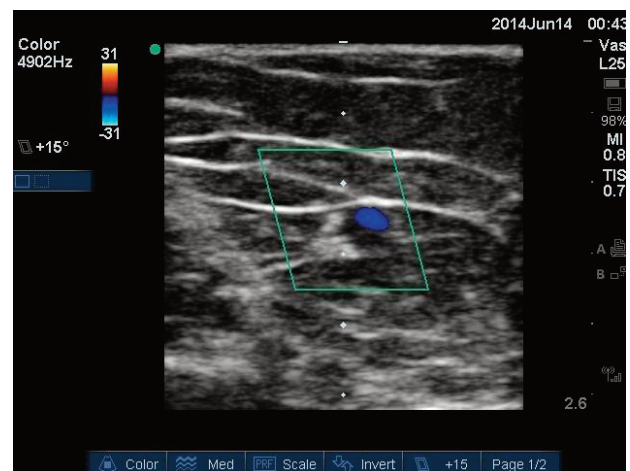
Short axis view of a peripheral vessel visualized with Color Doppler (blue). The scale on the right of the screen demonstrates a total depth of 2.6cm. A guide (white dots) in the center of the screen marks each 0.5cm of depth. Therefore the depth of the vessel is between 1-1.5cm deep to the skin surface.
